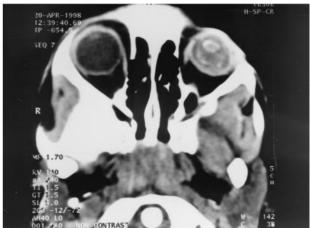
(Top) Photograph shows the mass in the vitreous seen behind the subluxated and cataractous lens. Surface vessels over the mass are evident. (Bottom) Axial computed tomography scan reveals calcification in the mass.
